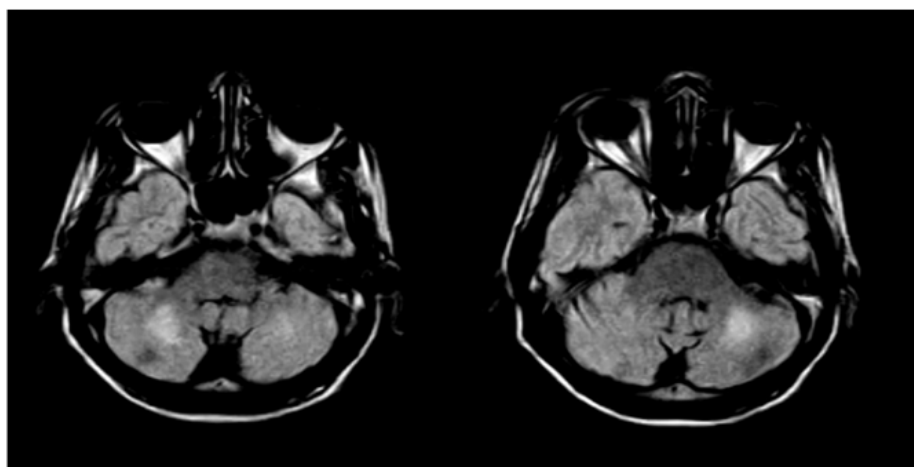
Axial FLAIR images showing bilateral and symmetrical cerebellar white matter base of middle cerebellar peduncles.
